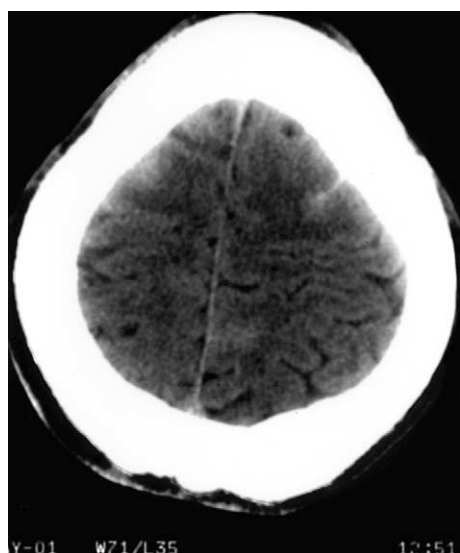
Non-contrast enhanced CT head scan demonstrating subtle subarachnoid haemorrhage within several parasagittal sulci on the left.
